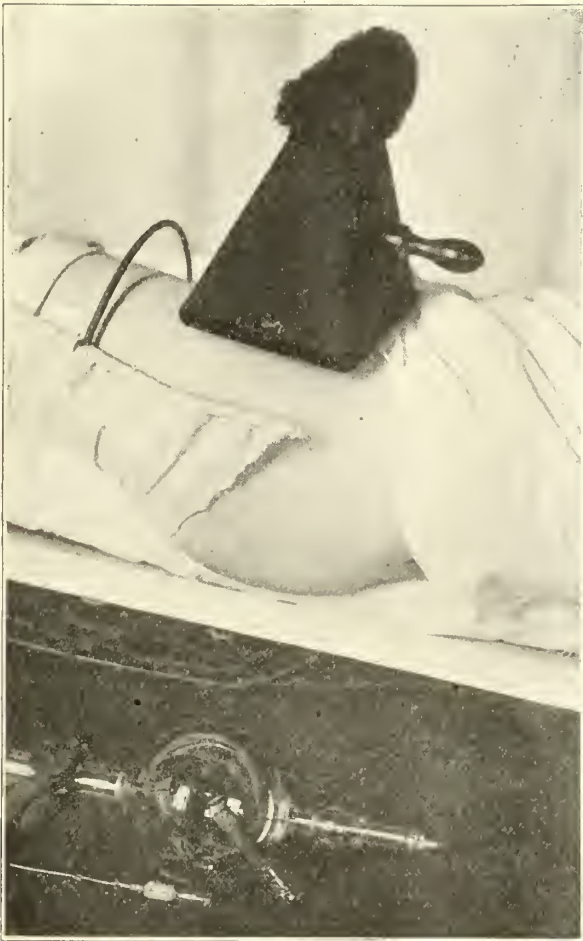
Looking down through the hip. The patient's hip is projecting over the edge of the bed. The free mobility of the patient permits the easy use of x-ray examination.
